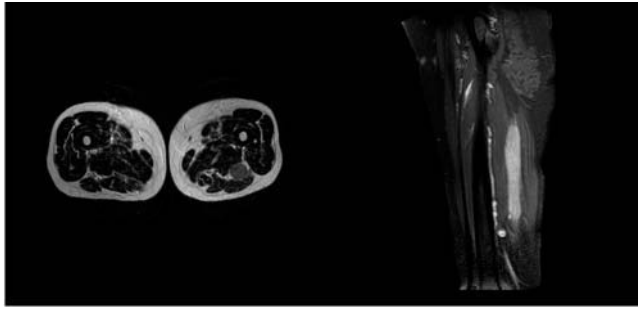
Magnetic resonance image of the left thigh. Axial plane T2 sequence showing a rounded tumour with slight hyperintensity with respect to muscle, with well-delimited edges, dependent on the common sciatic nerve (left). T1 sequence with fat suppression (SPIR) in sagittal plane after gadolinium administration showing an intense homogeneous enhancement of the lesion, with a fusiform morphology and approximate dimensions of 16×3 cm in craniocaudal and transverse direction, respectively (right).
